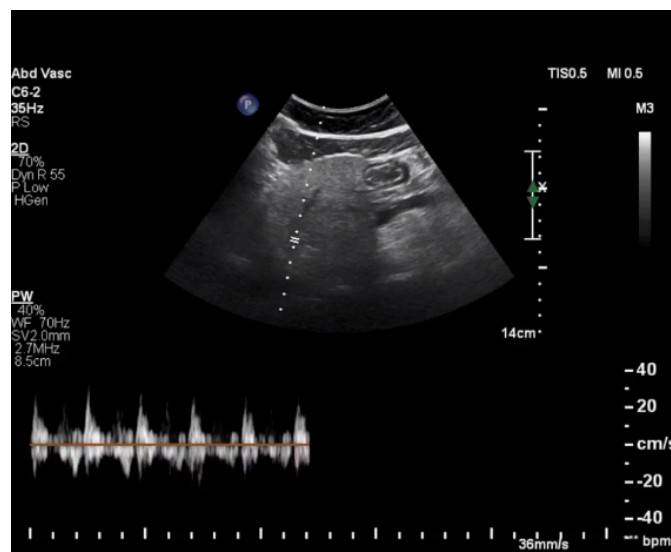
Hepatic vein Doppler waveform used for VExUS grading.
